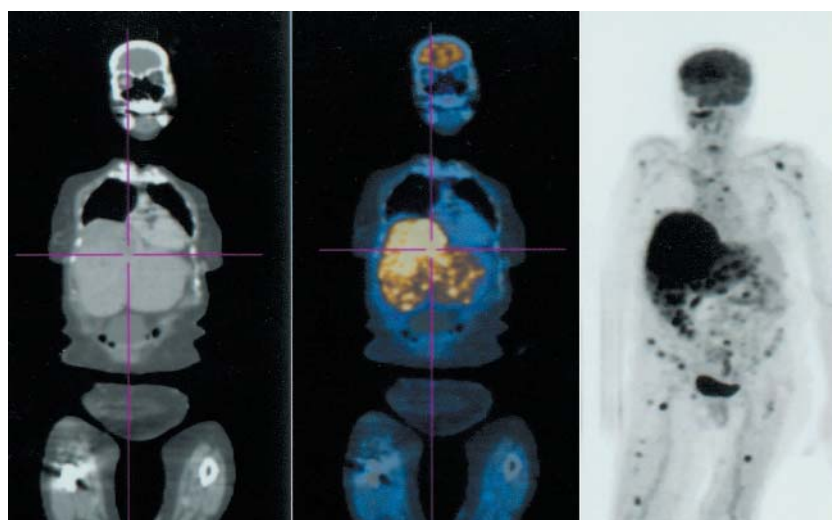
On the left, the CT demonstrates the anatomy; on the right the PET shows areas of hypermetabolism (glucose uptake); in the middle the two images are fused. PET/CT revealed enlarged para-aortic lymph nodes and a subcutaneous nodule in the anterior abdominal wall. The PET imaging portion of the PET/CT was able to reveal multiple bony metastases that were not seen on the CT portion of the examination. Both CT and PET showed a large liver metastasis.
